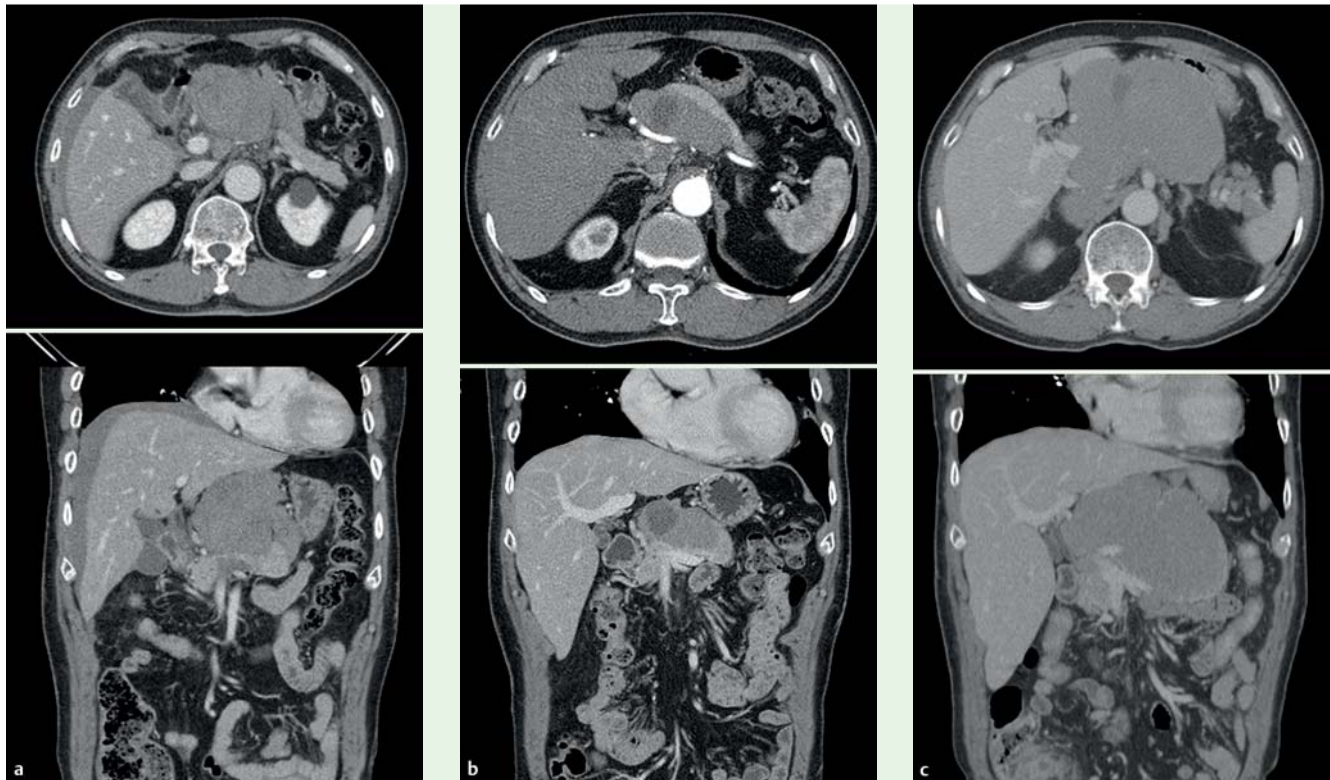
Evolving peripancreatic lesion. a Abdominal computed tomography immediately after a car accident shows an enhancing peripancreatic mass. b After 6 months, the lesion has shrunk. c A huge peripancreatic mass is incidentally identified following appendectomy 18 months after the injury.
